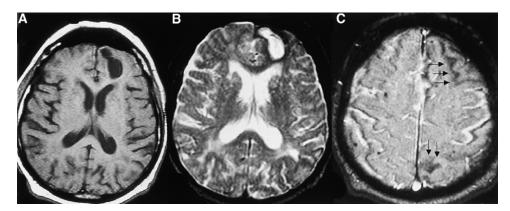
Gradient-echo MRI of a patient with previous microhemorrhages in multifocal regions typical of cerebral amyloid angiopathy. (A) T1-weighted image demonstrates an old lesion in the left frontal lobe. (B) T2-weighted image demonstrates a hemosiderin ring around the left frontal lesion. (C) Gradient-echo imaging demonstrates chronic microhemorrhages in the left frontal and left medial parietal region (*arrows*).
